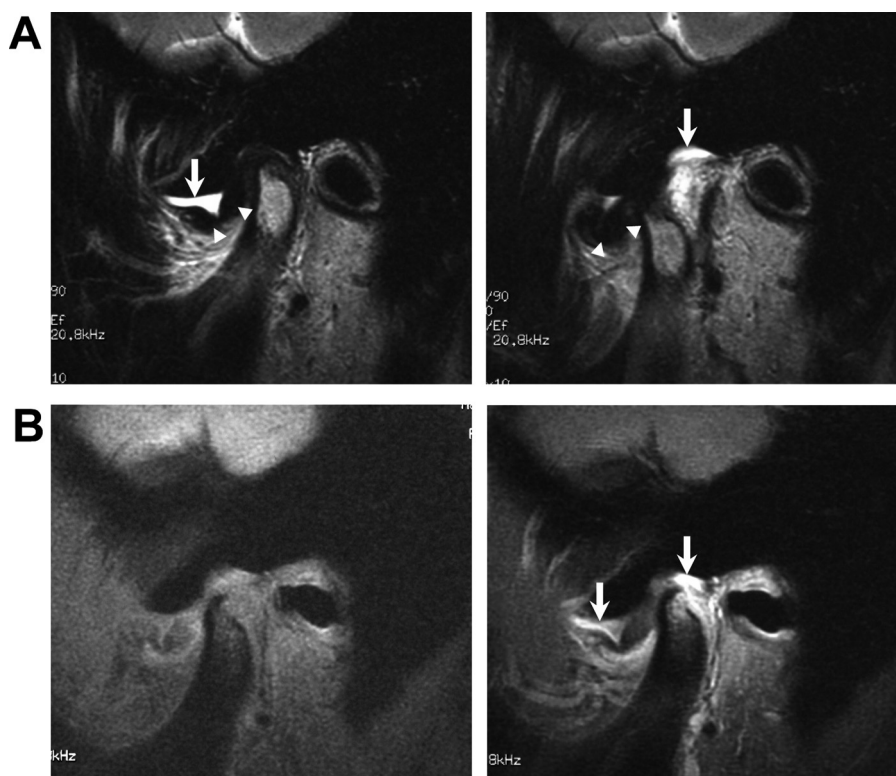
(A and B) A 47-year-old man with a recent history of left TMJ pain and MM pain. (A) Sagittal T2-weighted closed- (left) and open-mouth (right) MR images show marked effusion (arrows) above the displaced disk (arrowheads) and mandibular condyle. (B) Sagittal dynamic fat-suppressed T1-weighted pre- (left) and postcontrast (right) MR images demonstrate areas of enhancement corresponding to effusion (arrows). TMJ, temporomandibular joint; MM, masseter muscle.
